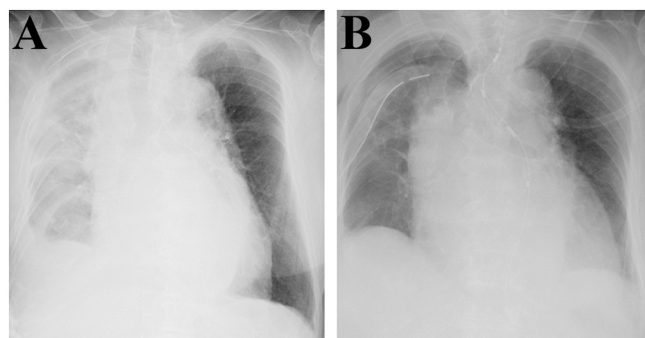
A chest drainage tube was inserted in the right chest (B); 800 ml bloody discharge was drained, and improved X-ray permeability is noted compared to X-ray on admission (A).
